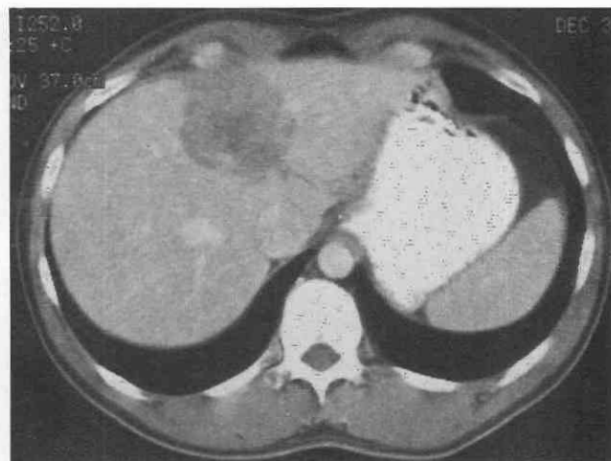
Non-Hodgkin's lymphoma in a 34-year-old man. Contrast-enhanced CT scan demonstrates a focal mass of low attenuation that extended into the portal region on more caudal images.
